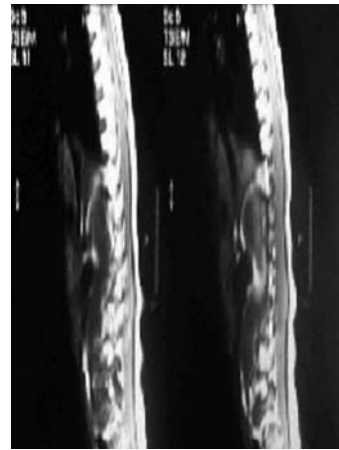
MRI of spine of patient which revealed a non-homogenous cystic intramedullary mass from 10th to 12th vertebrae distorting the cord.
